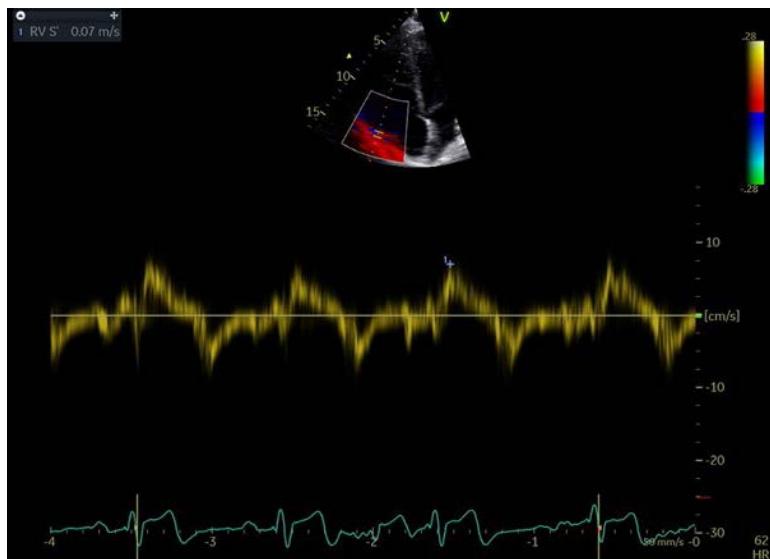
Echocardiography tissue Doppler showing a right ventricular S'- wave of 7 cm/s indicating right ventricle systolic dysfunction.
